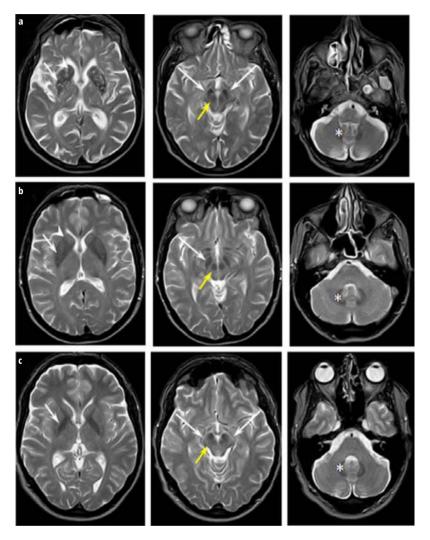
Axial SE T_2W MR images of the father (a), the daughter (b) and the son (c). Showed hypointensity in caudate nuclei (head arrows), lenticular nuclei (short white arrows), dentate nuclei (asterisks), substantia nigra pars compacta (long white arrows) and red nuclei (yellow arrows) suggesting an increase of ferromagnetic deposits.
